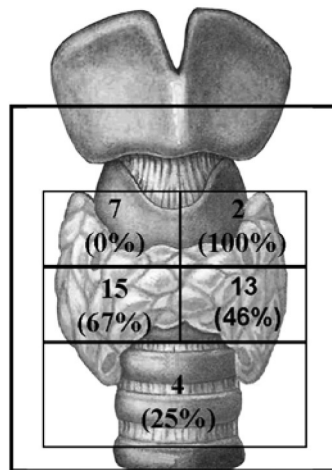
Combined number of pathological parathyroid glands identified at initial (n=23) and at revision surgery (n=18) in each of the four quadrants of the neck and the mediastinum. The sensitivity of Tc99m-MIBI-SPECT for localization in each of these four quadrants of the neck and the mediastinum is shown in parentheses.
